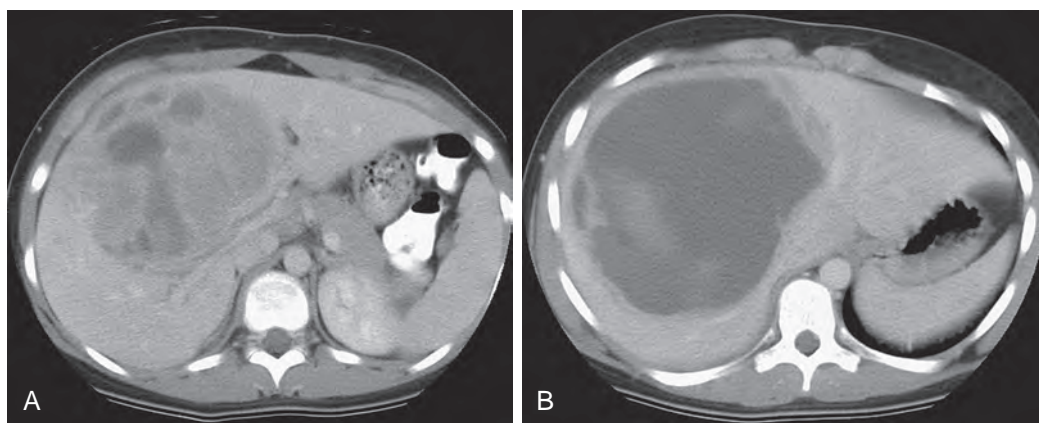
Adenoma with hemorrhage. A and B. Axial CT images after intravenous contrast enhancement in an 11-year-old girl who experienced acute onset of abdominal pain after karate class. The large, hemorrhagic tumor occupying the right hepatic lobe was found to be an adenoma at resection.
